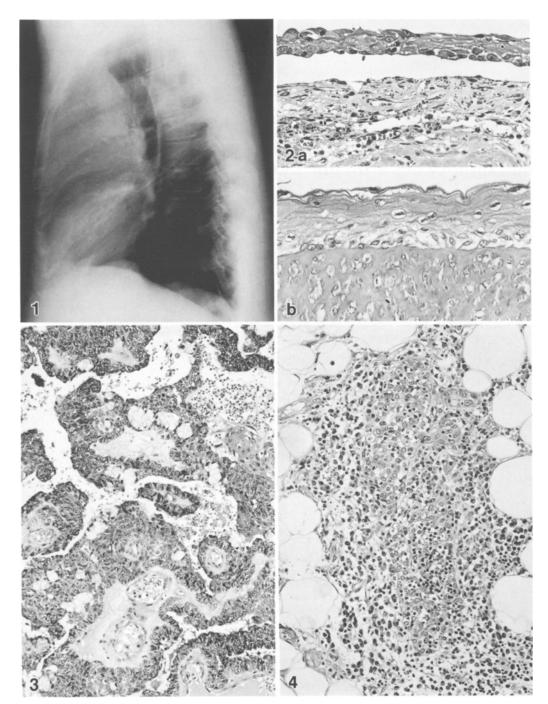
Chest X-ray. A large cystic lesion occupies the anterior mediastinum and projects into the left lung field
